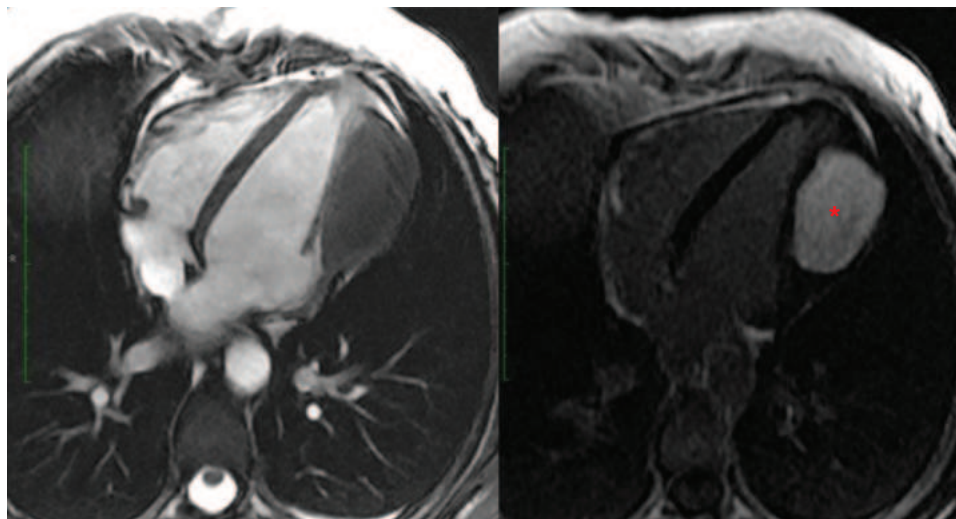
A case of a cardiac fibroma. A patient presented with shortness of breath and was found to have a large myocardial mass on echocardiography. Cine cardiac magnetic resonance imaging confirmed the large myocardial mass involving the anterolateral wall. Shortly after gadolinium contrast was injected, the myocardial mass demonstrated intense accumulation of contrast on late gadolinium enhancement imaging (right panel, asterisk). This is a case of cardiac fibroma. The patient also has gingival hyperplasia and bifid thoracic ribs, a part of the rare Gorlin's syndrome.
